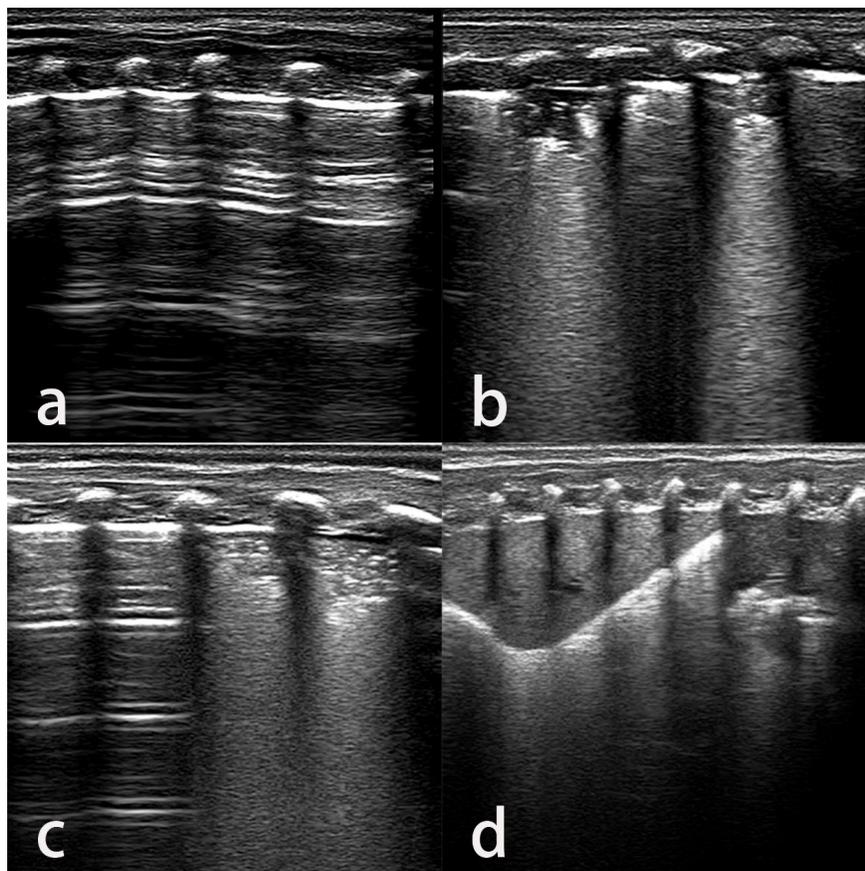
Lung ultrasound findings of normal lung and pneumonia in neonates: a. Normal lung b. Mild pulmonary consolidation (mild pneumonia): the consolidation extent was limited to the pleural line, involving only one intercostal space; c. Moderate pulmonary consolidation (mild pneumonia): the consolidation involved 2-3 intercostal spaces. d. Extensive lung consolidation (severe pneumonia): involving more than three intercostal spaces.
